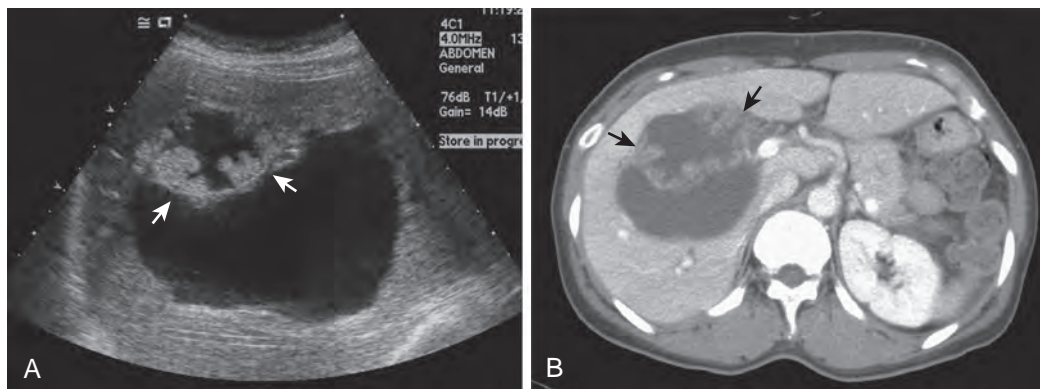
Biliary cystadenocarcinoma. A. Transverse sonogram shows a large, lobulated cystic mass with thick septation and multiple mural nodules (arrows). B. CT scan shows a lobulated cystic mass with thick septation and enhancing mural nodules (arrows).
